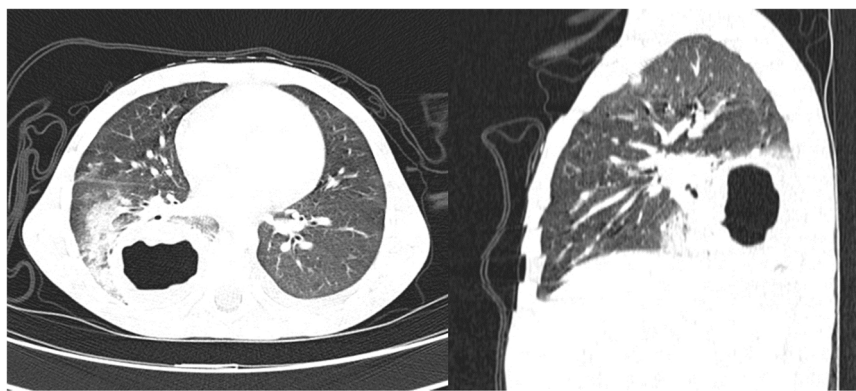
Axial (left) and sagittal (right) computed tomography images in lung window performed on day-8 of hospitalization depicting a thick-walled cavity in the right lower lobe with consolidation of the surrounding lung parenchyma.
